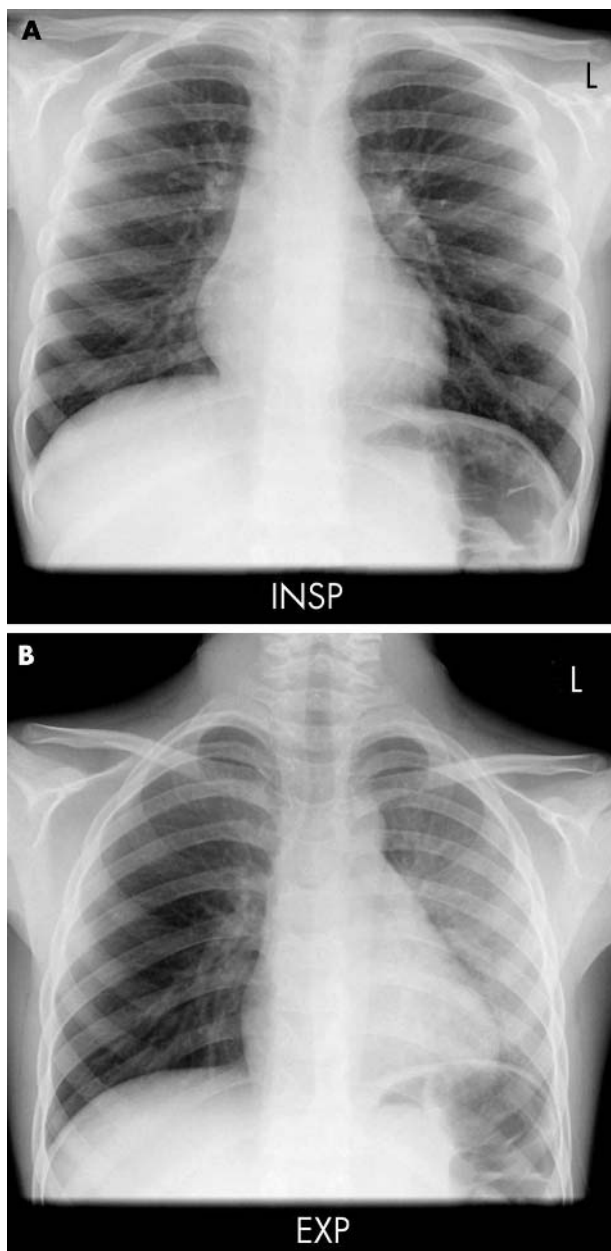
Case 1: inspiratory and expiratory chest radiographs.
